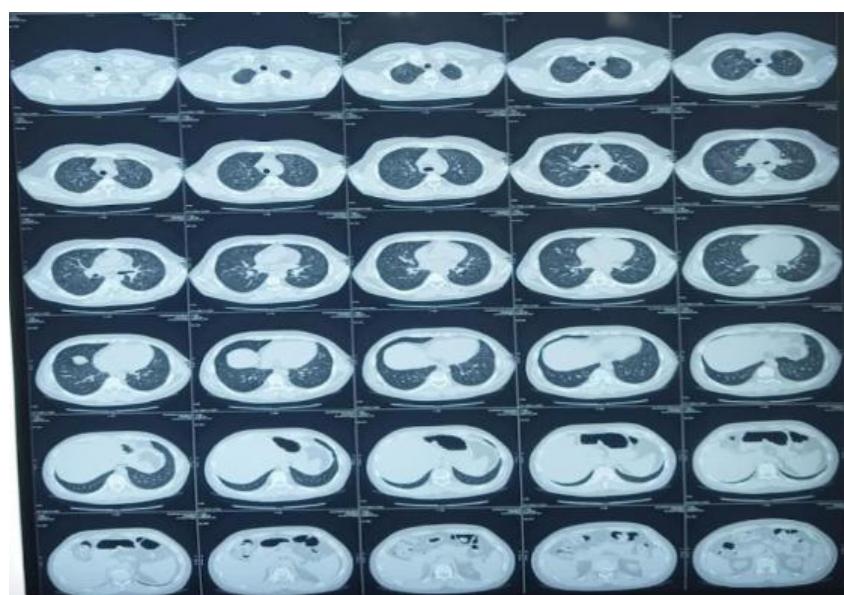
HRCT chest (lung window) – bilateral diffuse ground-glass opacities with fibro-atelectatic changes in basal segments (old healed changes)
